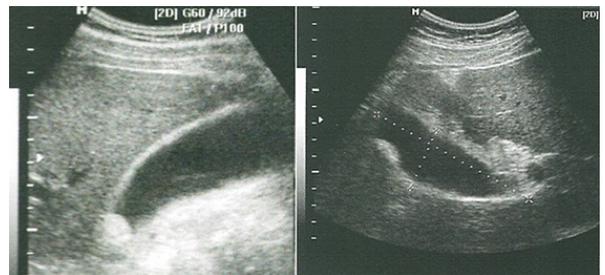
Ultrasonography showing a distended gallbladder (11 cm on longitudinal axis) with wall thickening, containing sludge and mobile microlithiasis.
